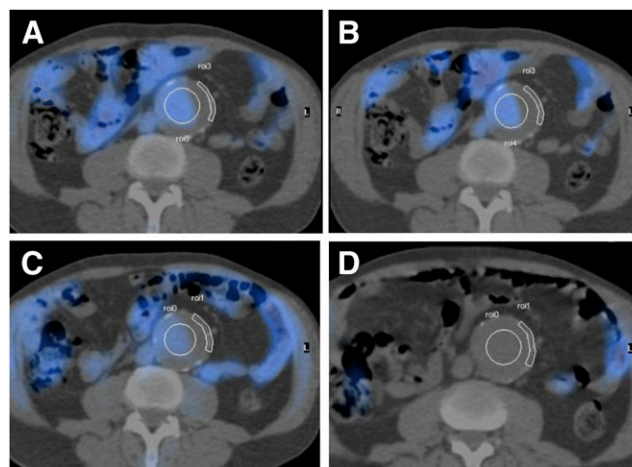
Fused axial PET/CT of ROIs applied to aortic aneurysmal wall and lumen at mid-point of dynamic acquisitions at 45 (A), 60 (B), 120 (C), and 180 min (D) after injection of ¹⁸F-FDG.
